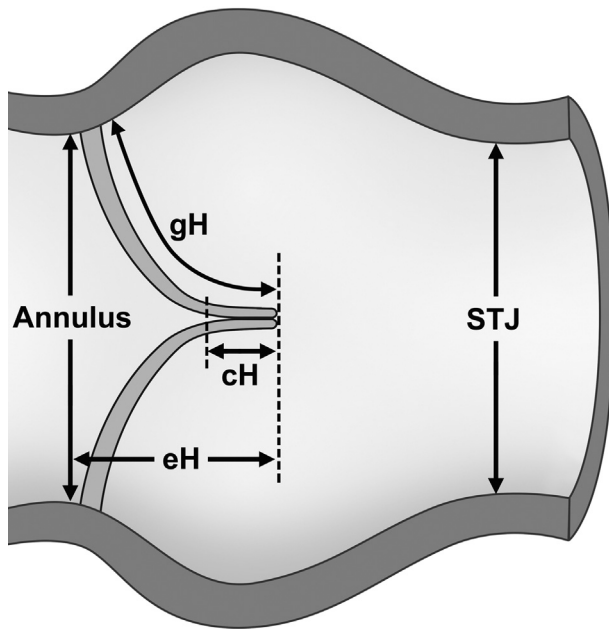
Echocardiographic measurements of the aortic root performed in the preprocedure assessment for aortic valve repair. Abbreviations: *cH*, Coaptation height; *eH*, effective height; *gH*, geometric height of the aortic valve cusps, *STJ*, sinotubular junction. Redrawn from Berrebi A, Monin JL, and Lansac E, Systematic echocardiographic assessment of aortic regurgitation-what should the surgeon know for aortic valve repair? *Ann Cardiothorac Surg* 2019; 8:331-341.
